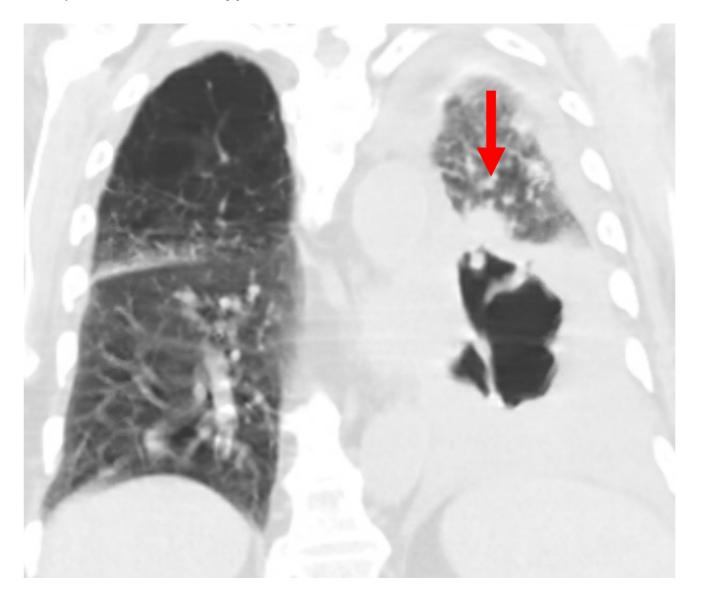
CT scan of Case 1 showing necrotic lung mass
